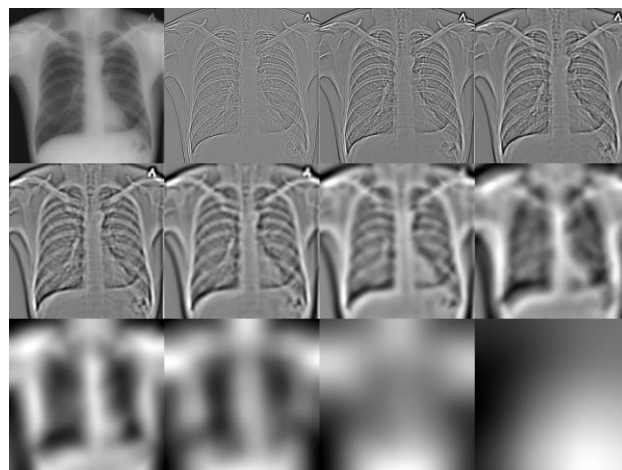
A chest X-ray and some of its BIMFs obtained by FABEMD in ascending order of the BIMF number
